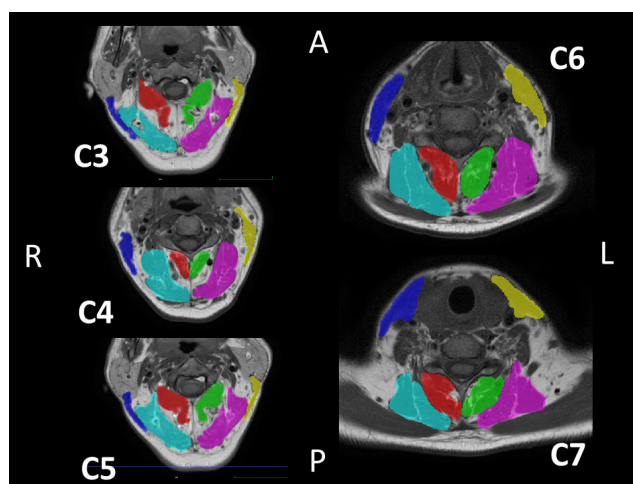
Magnetic resonance imaging (MRI) data of axial sections of the multifidus (M), semispinalis cervicis (SC), semispinalis capitis (SCP), splenius capitis (SPLC), and sternocleidomastoid (SCM) muscles in the C3–C7 range marked with various colors using ITK-SNAP software
